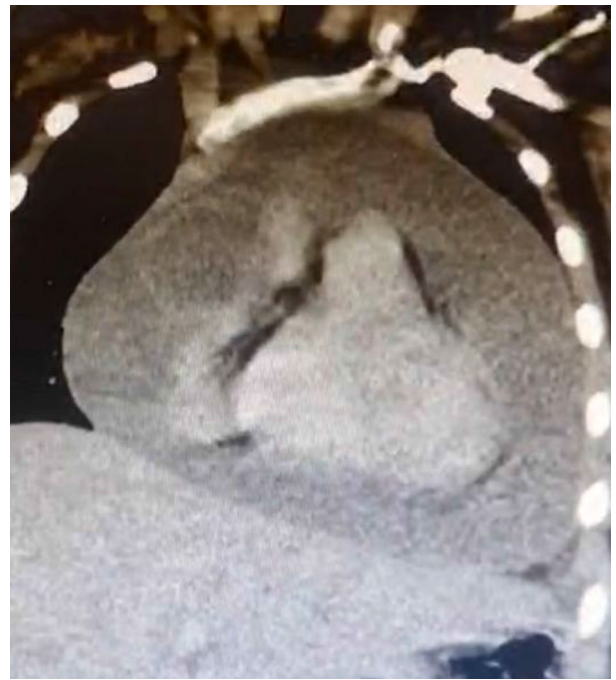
Computed tomography image of the pericardial cyst and pericardial tamponade.
